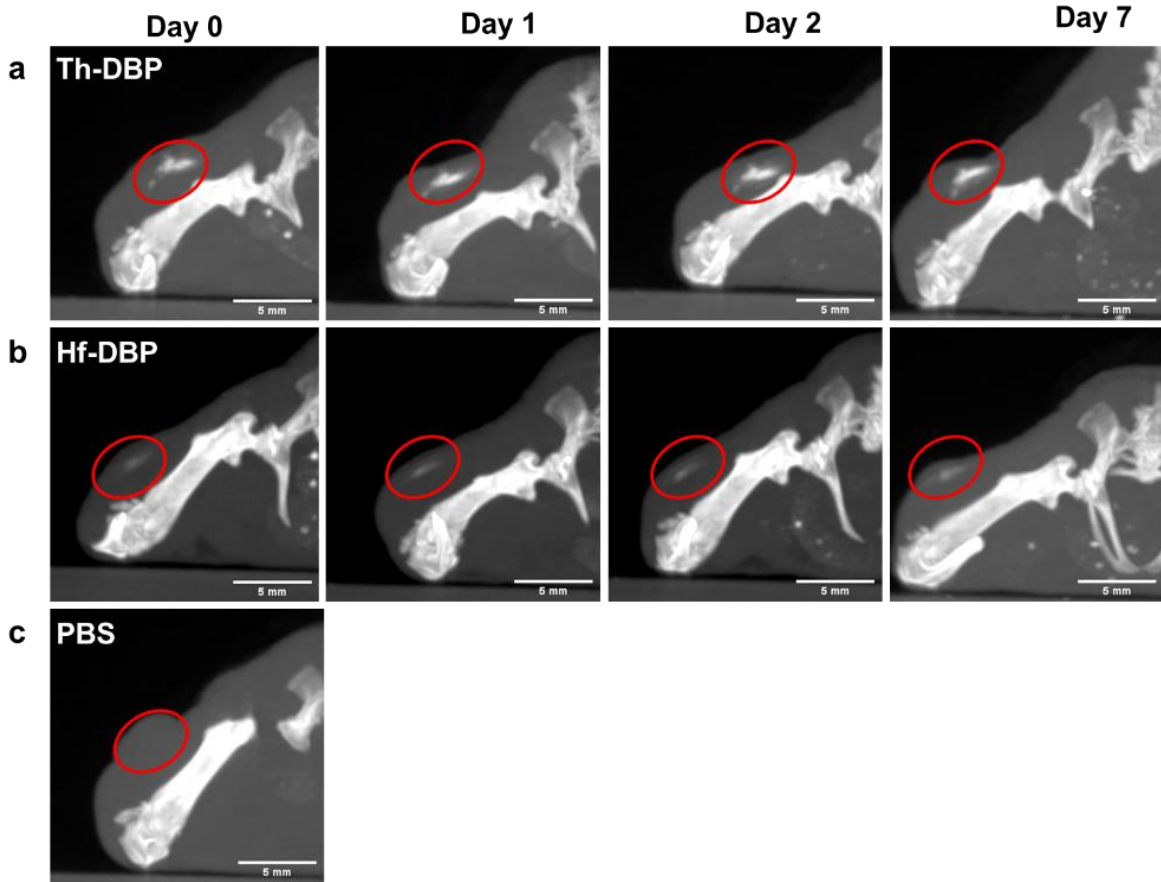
CT images showing tumoral contrast at different timepoints after injection of Th-DBP (a), Hf-DBP (b), and PBS (c) (scale bar = 5 mm).
